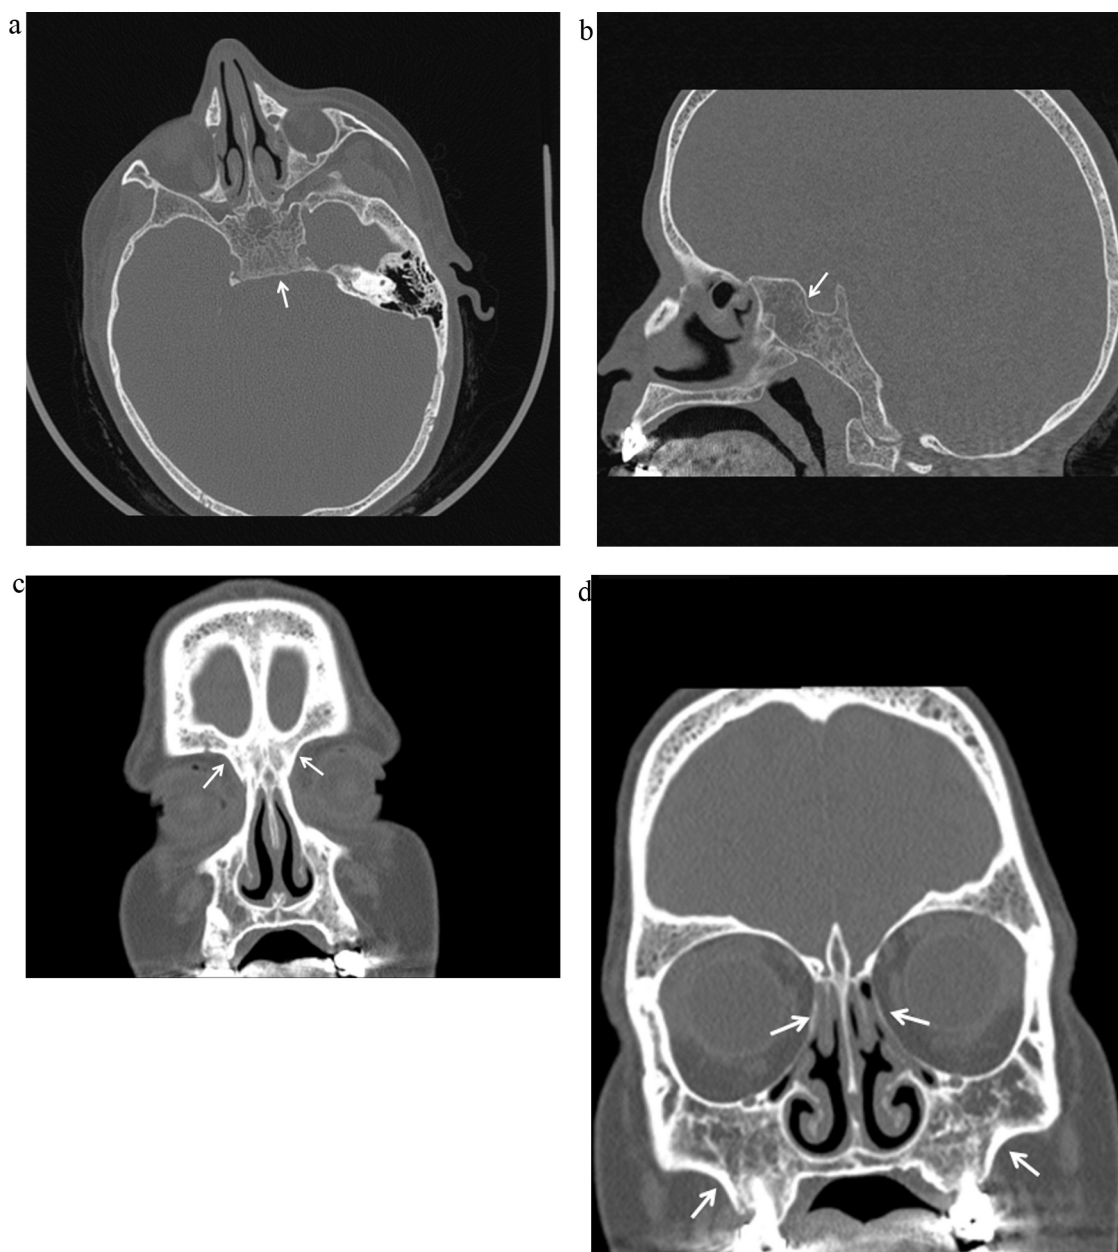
Axial, coronal and sagittal CT scans shows aplasia of the maxillary, frontal and sphenoid sinuses, and the hypoplasia of ethmoid sinuses (white arrows).
